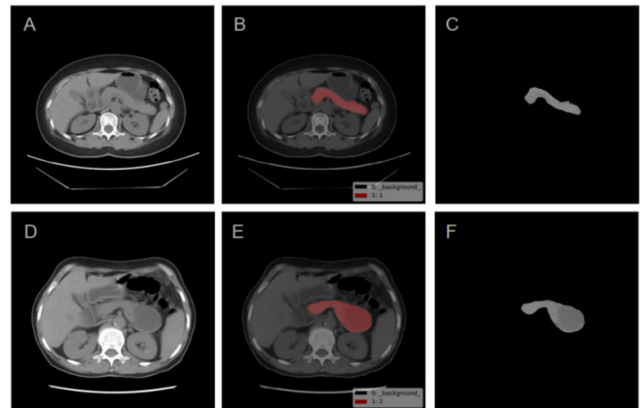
The pancreatic ROI segmentation. A. Normal CT image. B. ROI drawn on a pancreas image with the normal (red area). C. Normal segmentation. D. Stage IV CT image. E. ROI drawn on a pancreas image with the stage IV (red area). F. Stage IV segmentation.
